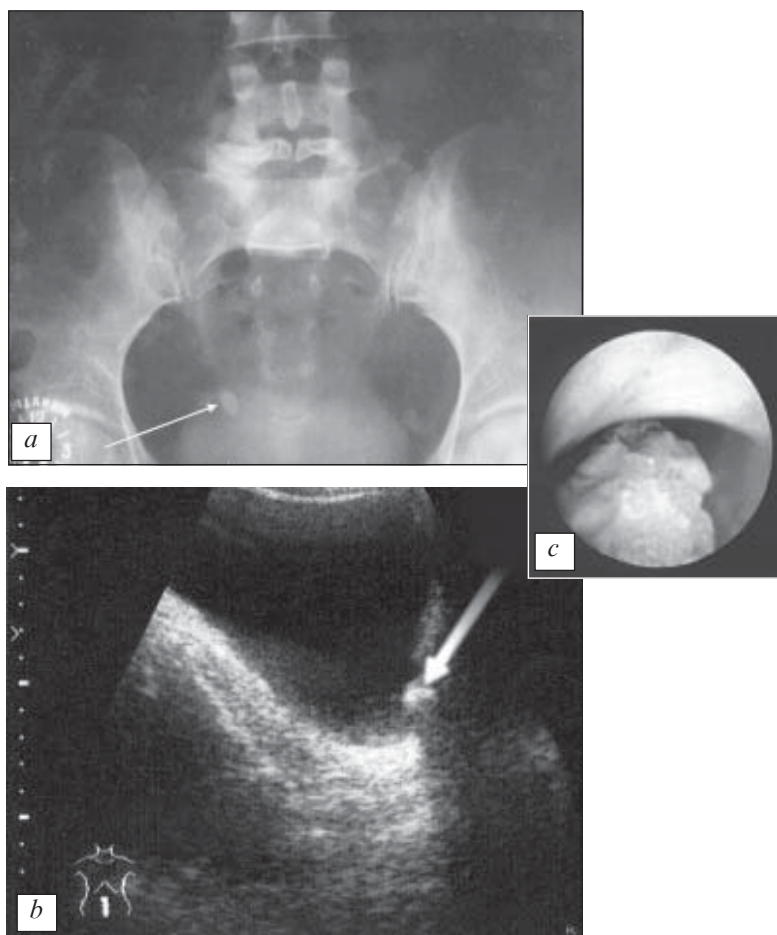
Stones in the urinary tracts: *a* — X-ray contrast concrement in the lower third part of the urethra (survey urogram); *b* — echo-positive stone of the ureter ostium (US); *c* — endoscopic picture of the same stone (ureteroscopy)
